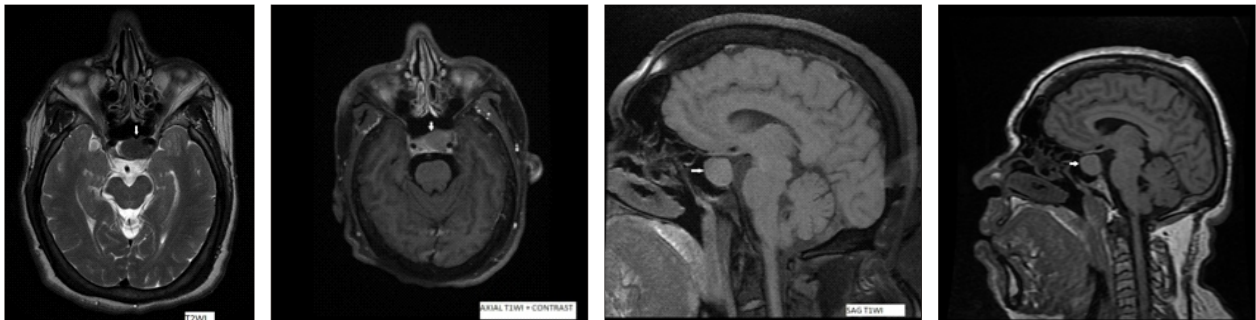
MRI Brain with contrast showing the pituitary macroadenoma in various views.(arrows)
